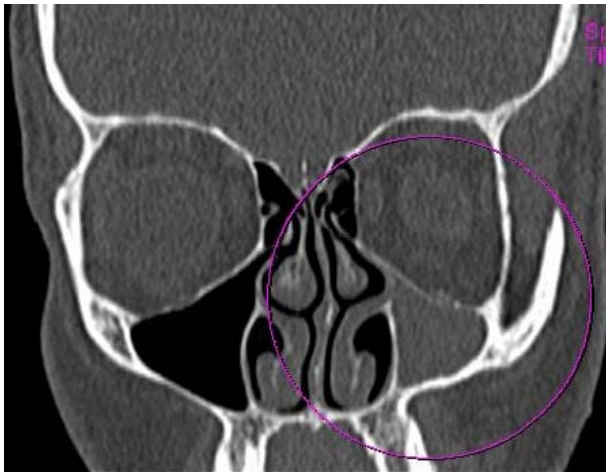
Coronal computed tomography (CT) scan: lateralized left uncinete process and medial maxillary sinus wall, enlarged left middle meatus, completely opacified left maxillary sinus, and its volume decreased.
